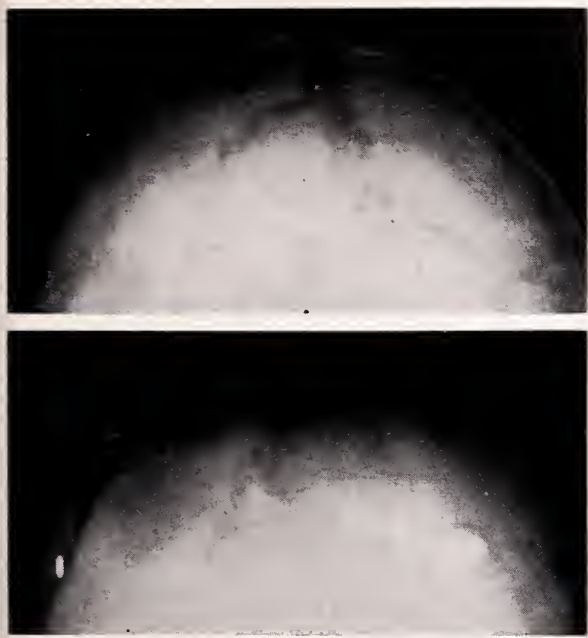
X-rays showing (above) preoperative separation of sagittal suture and (below) postoperative normal suture following removal of subdural hematoma and release of increased intracranial pressure.
